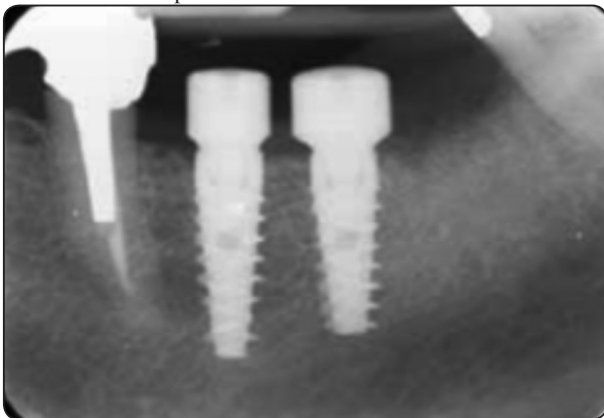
Postoperative periapical radiograph showing implants inserted to restore missing first and second molars
